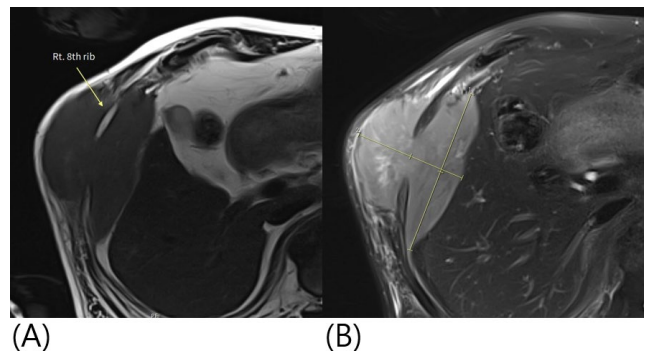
Magnetic resonance imaging of the right chest wall lesion. (A) The lesion encasing the right 8th rib. (B) Axial MRI demonstrating a soft tissue mass in the right anterolateral chest wall measuring approximately 9.5 × 6.4 × 11.9 cm.
